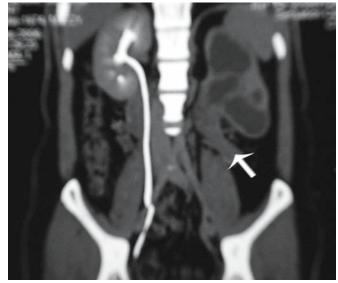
A computed tomography (CT) scan shows a tumor (arrow) in the left upperureter
